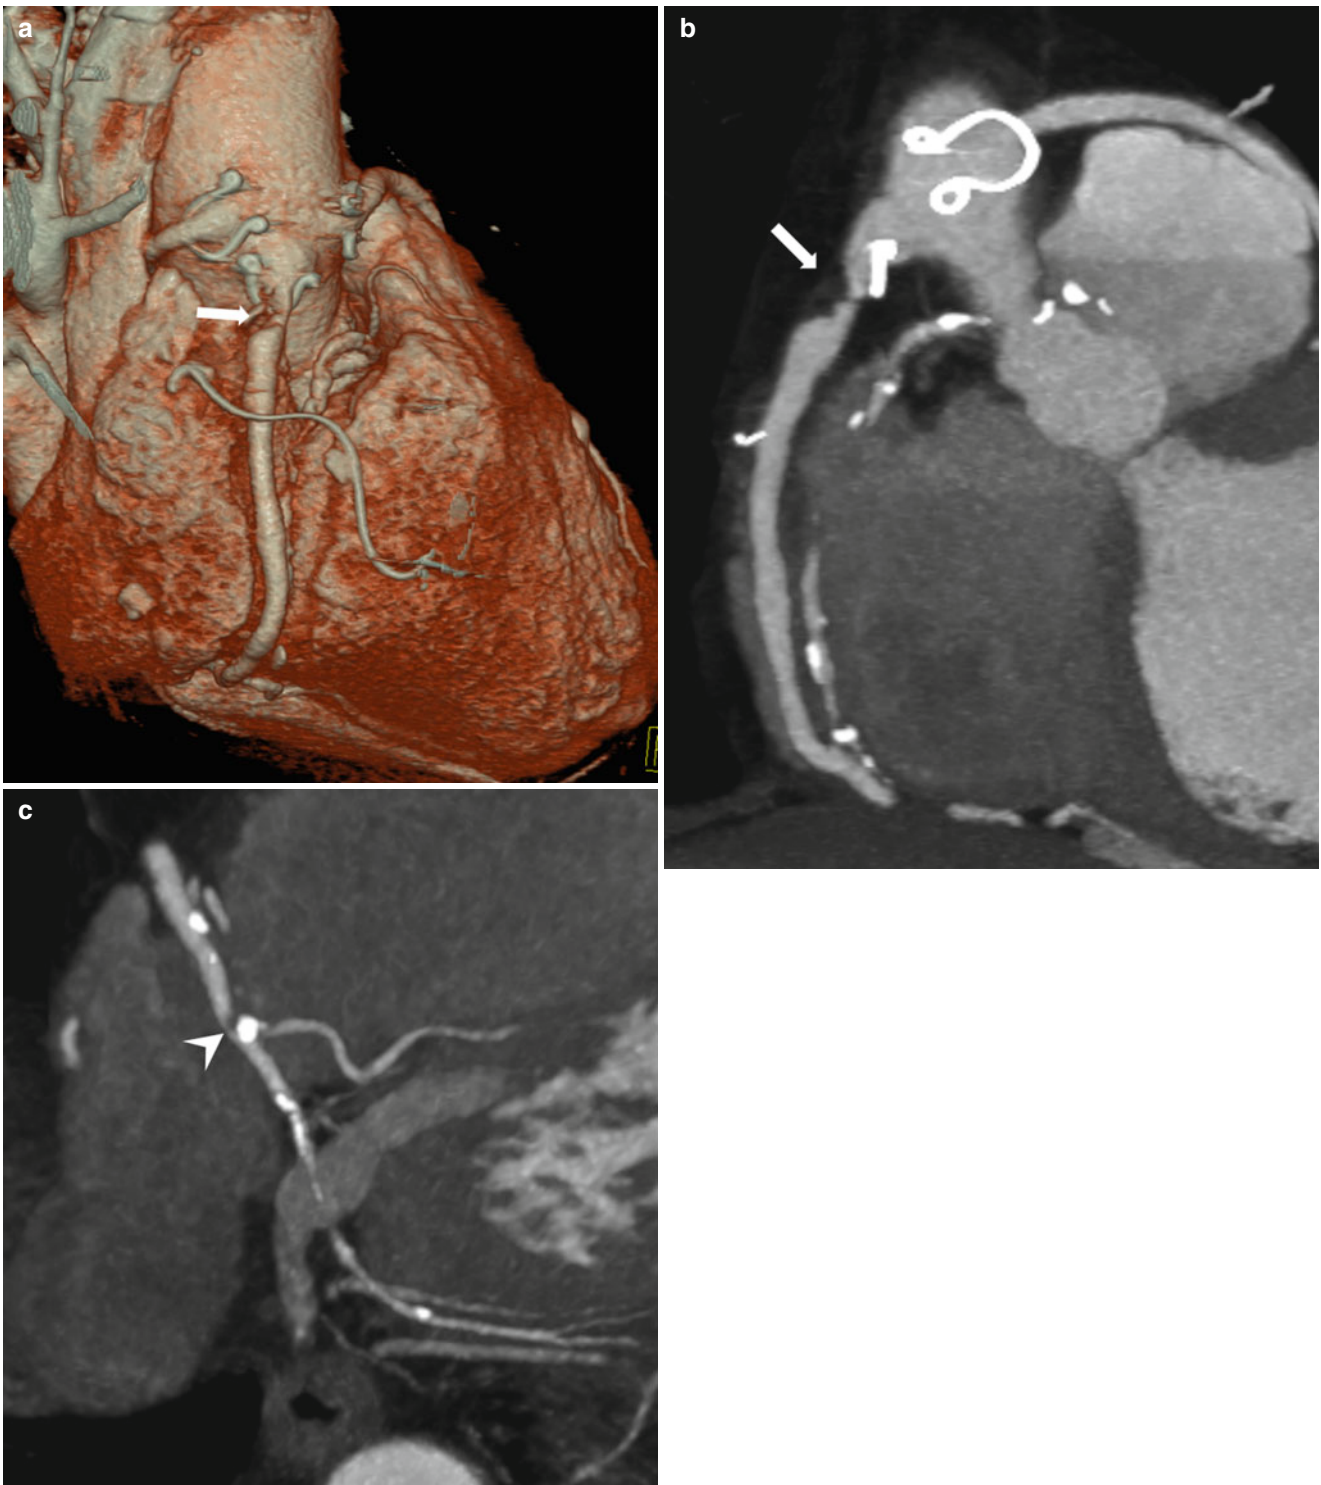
Severe stenosis in free saphenous vein graft involving both proximal and distal portion of the graft. (a) Volume rendering and (b) oblique coronal CT images demonstrated severe stenosis (arrows) in the proximal portion of the saphenous vein graft from the ascending
